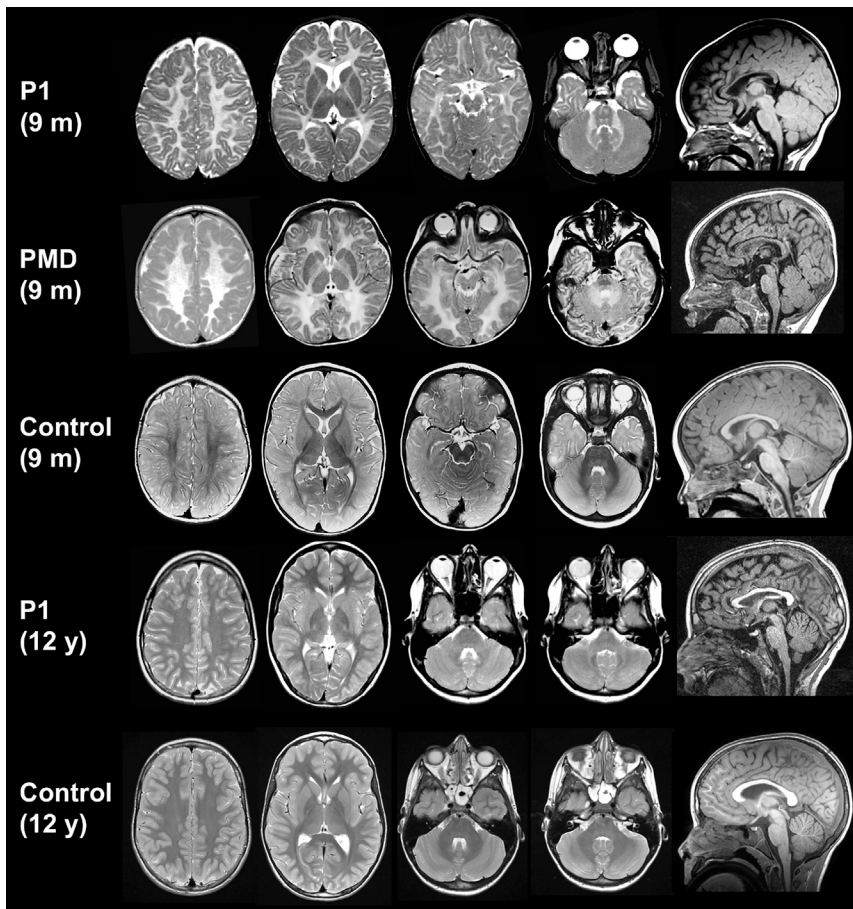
MRI Evolution of Individual 1 Axial T₂-weighted images and a mid-sagittal T₁-weighted image of individual 1 at 9 months and 12 years of age, shown in comparison with age-matched control subjects and an individual with PMD aged 9 months. At 9 months, MRI findings are indistinguishable from PMD, with supra- and infratentorial white matter signal that is diffusely elevated on the T₂-weighted images. The corpus callosum is thinner than normal. At age 12 years, supratentorial white matter signal has normalized, but there is still mild hyperintensity of the cerebellar white matter and the middle cerebellar peduncles.
